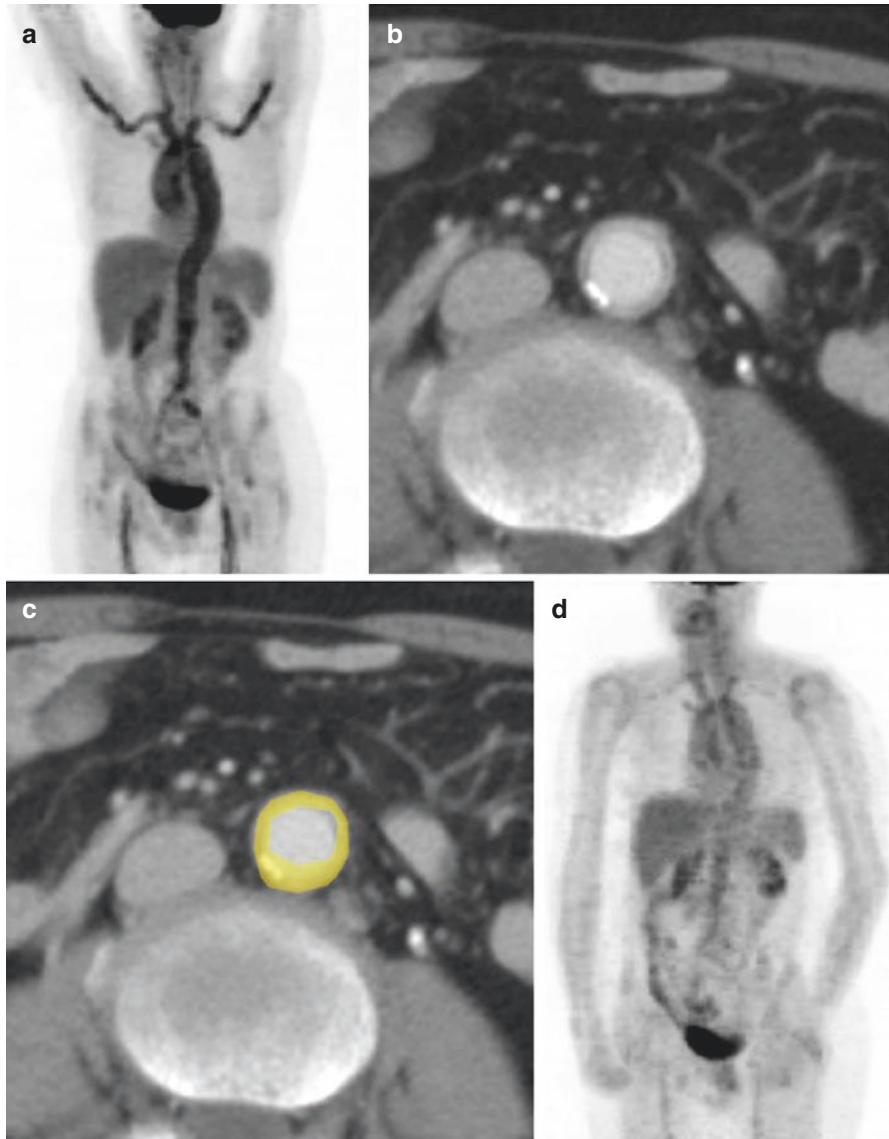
A case study—a 66-year-old woman. (a) PET-MIP (maximum intensity projections, summed pseudo 3D image) of the body evidencing active vasculitis. High FDG accumulation in the aorta and large arteries exceeding the reference liver accumulation t . (b, c) CTA was performed due to suspected vasculitis; a fine soft-tissue border in the aortic wall correlates in fusion of both examinations with metabolically active aortic wall (*yellow ring*). (d) Follow-up PET examination after 7 months of glucocorticoid therapy demonstrates decrease in FDG accumulation in large arteries
